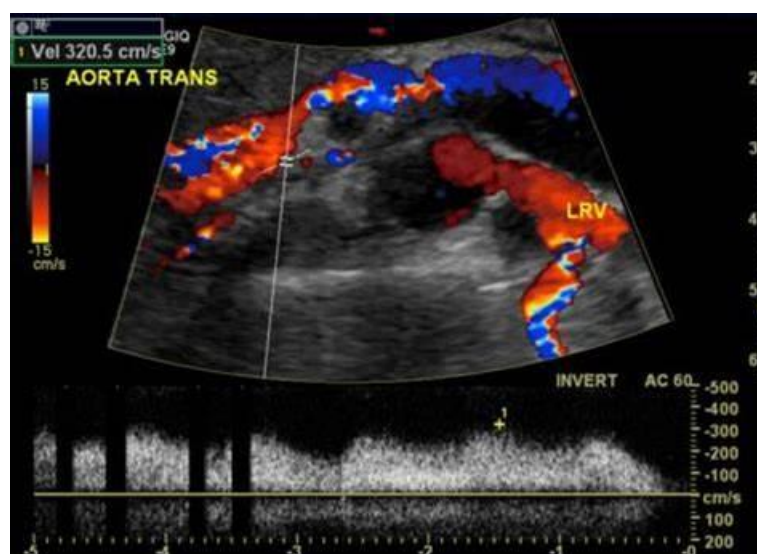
Doppler ultrasound demonstrating increased velocity in the compression area of left renal vein between aorta and superior mesenteric artery
